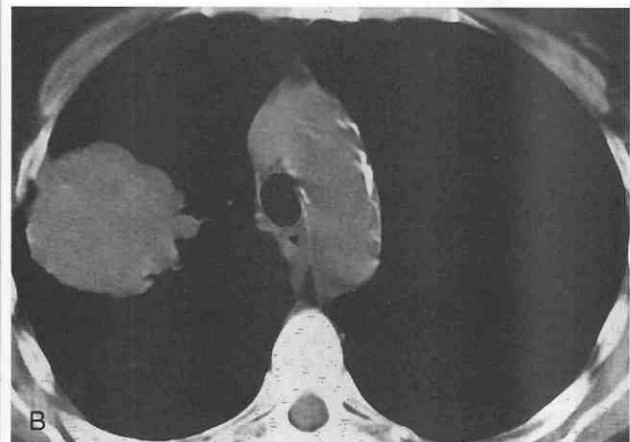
Adenocarcinoma manifesting as a pulmonary nodule. CT scan shows a nodule in the apical segment of the right upper lobe. The spiculated margin is typical of lung cancer.
